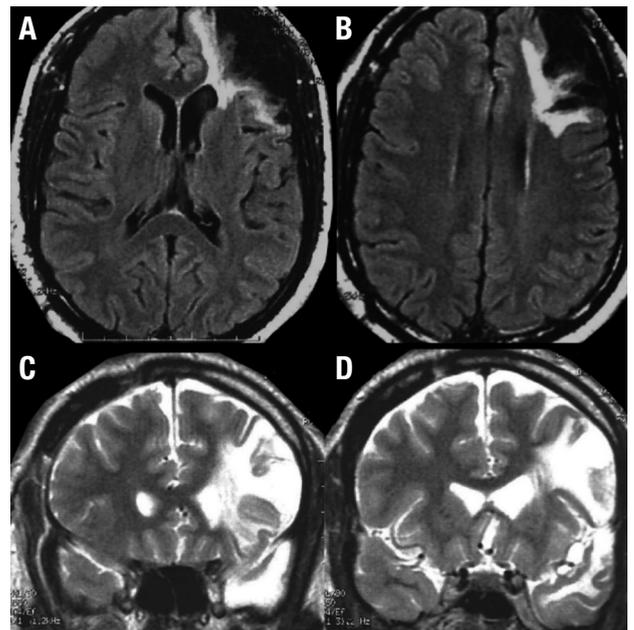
Brain MRI. [A, B] Axial FLAIR. [C, D] coronal T2WI. Reveals a large area of encephalomalacia and surrounding gliosis involving left frontal lobe. There is ex-vacuo dilatation of the left lateral ventricle.
